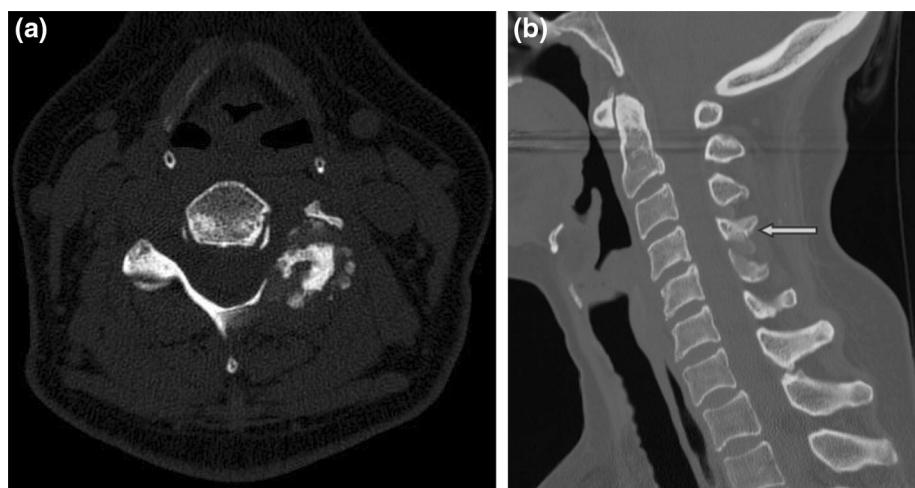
a Axial and b sagittal CT scan exhibiting reparative remodeling of the posterior arch of C4
